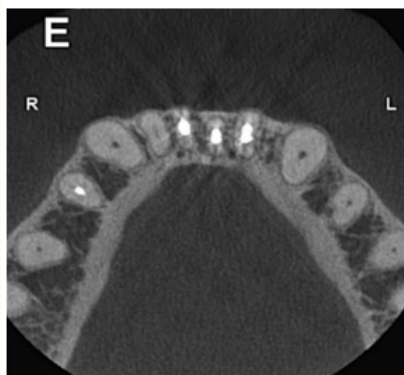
Specific CBCT slice (transaxial), one-year follow-up and bone repair in element 31 apical region.
